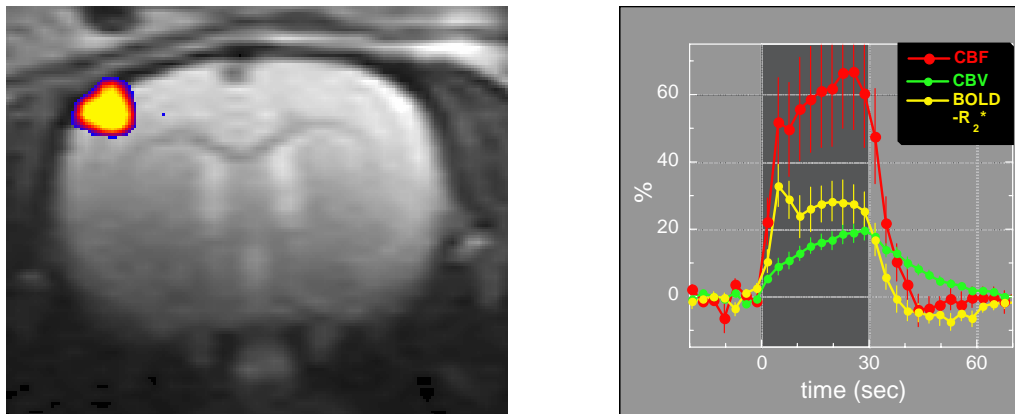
Images of the spatial and temporal responses to electrical forepaw stimulation measured with functional MRI.
